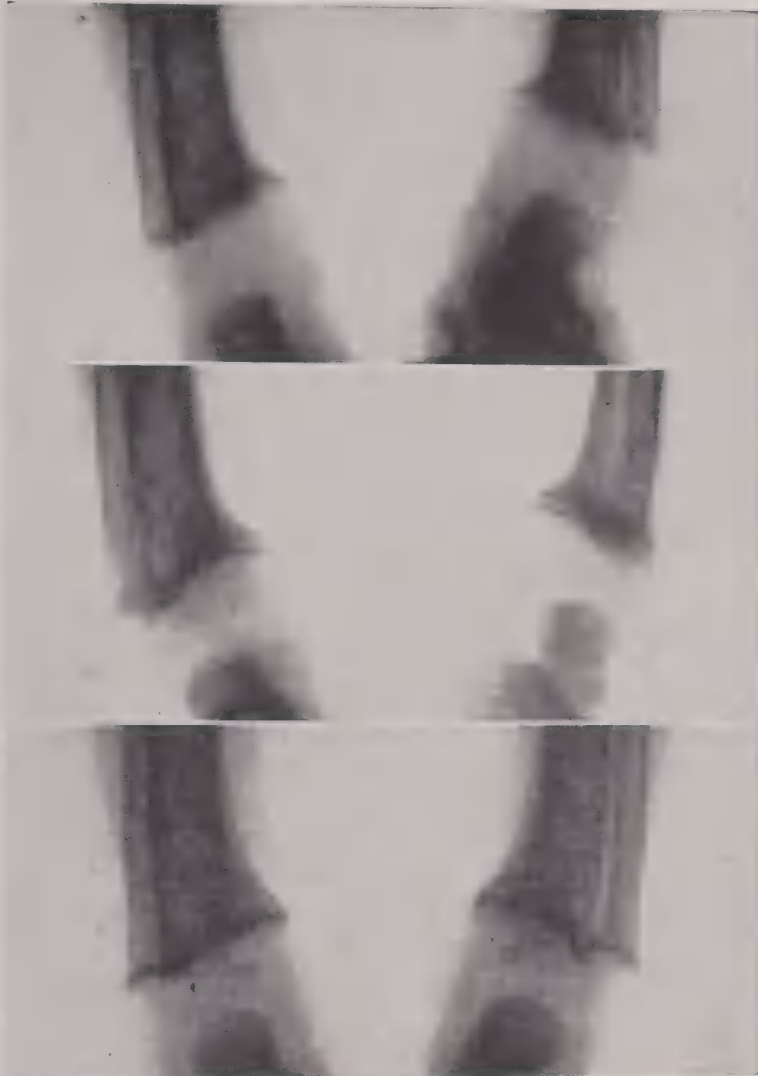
X-rays of the forearms and legs of a rachitic child, showing the effect of treatment.
